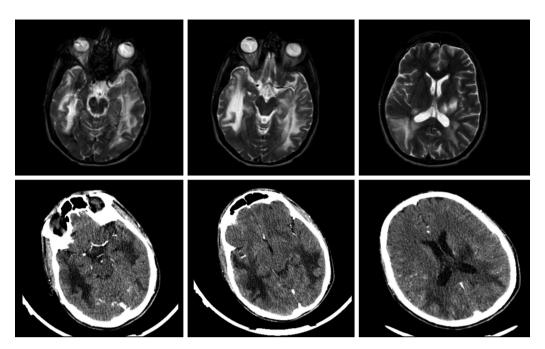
T2-weighted images (top) and cranial CT images (bottom) of patient 5 with progressive multifocal leukoencephalopathy CT: Computed tomography
